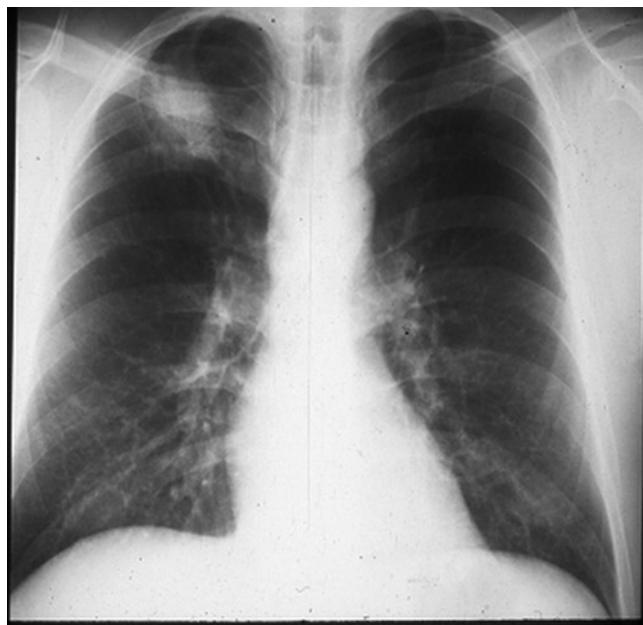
Chest X-ray of a patient with a right upper lobe nonsmall cell lung cancer scheduled for VATS lobectomy. The patient has moderate COPD as evidenced by the hyperinflation of the lungs and the narrow cardiac silhouette.
